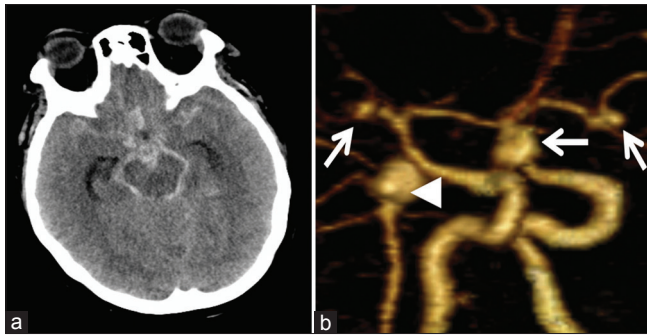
Initial presentation with diffuse subarachnoid hemorrhage around basal cisterns (a) and CTA demonstrating a basilar apex aneurysm (arrow head) as probable source and three additional anterior communicating aneurysms (arrows)
